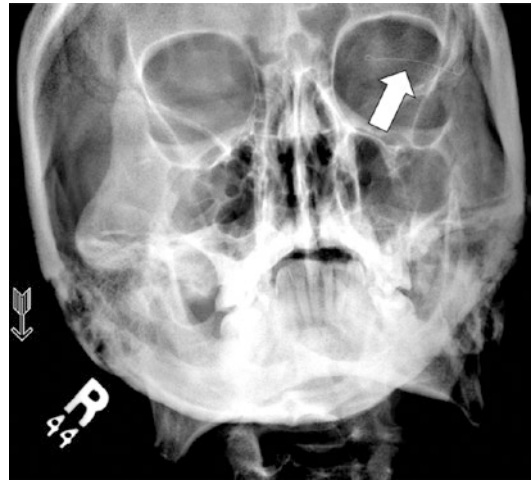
Radiograph of the orbits demonstrating the presence of a metal eyelid spring projecting over the left orbit (arrow)
